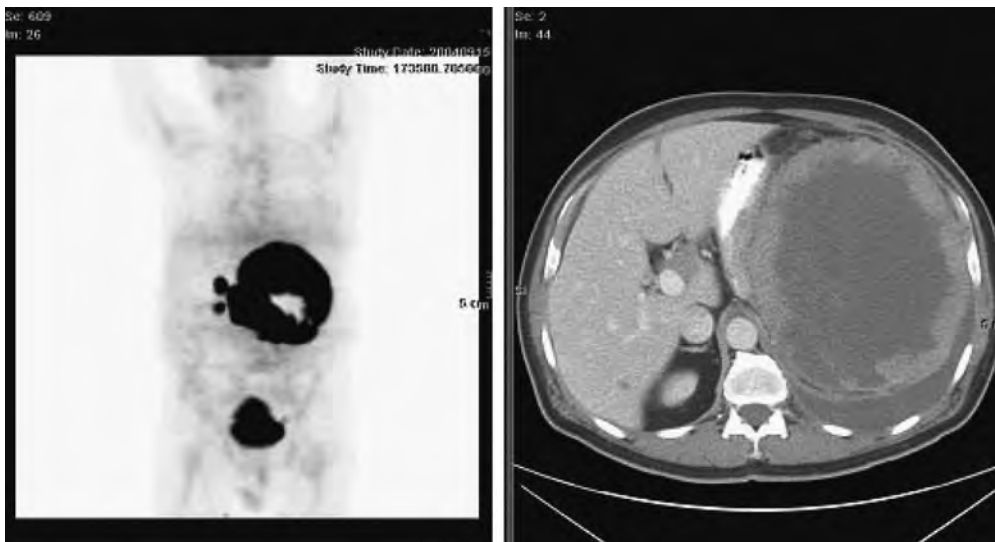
Large B-cell lymphoma. Left, PET maximum intensity projection image demonstrates a large peripheral area of increased fluorine-18-deoxyglucose (FDG) uptake with a central hypometabolic region involving the spleen. Right, Corresponding CT image after intravenous administration of contrast material demonstrates a large, hypodense, necrotic mass involving the central spleen. (Courtesy R. Attariwala, MD, PhD, Vancouver, Canada.)
